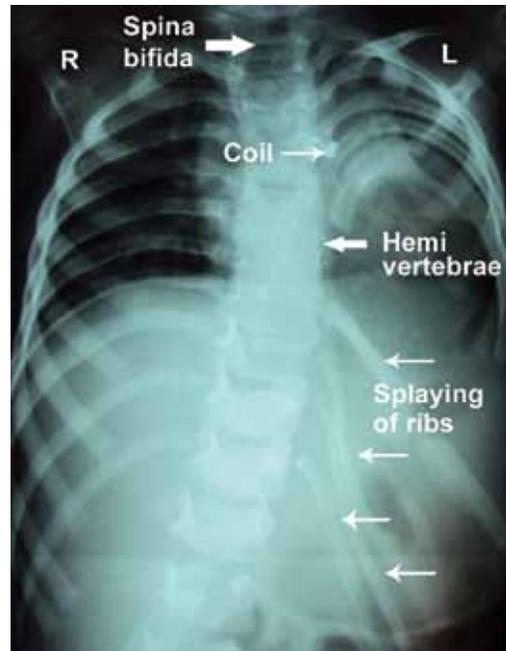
Chest X-ray in a 2 years old child with meningocele, shows spina bifida, hemivertebrae (arrow) with splaying of left lower ribs and the PDA coil is in situ
